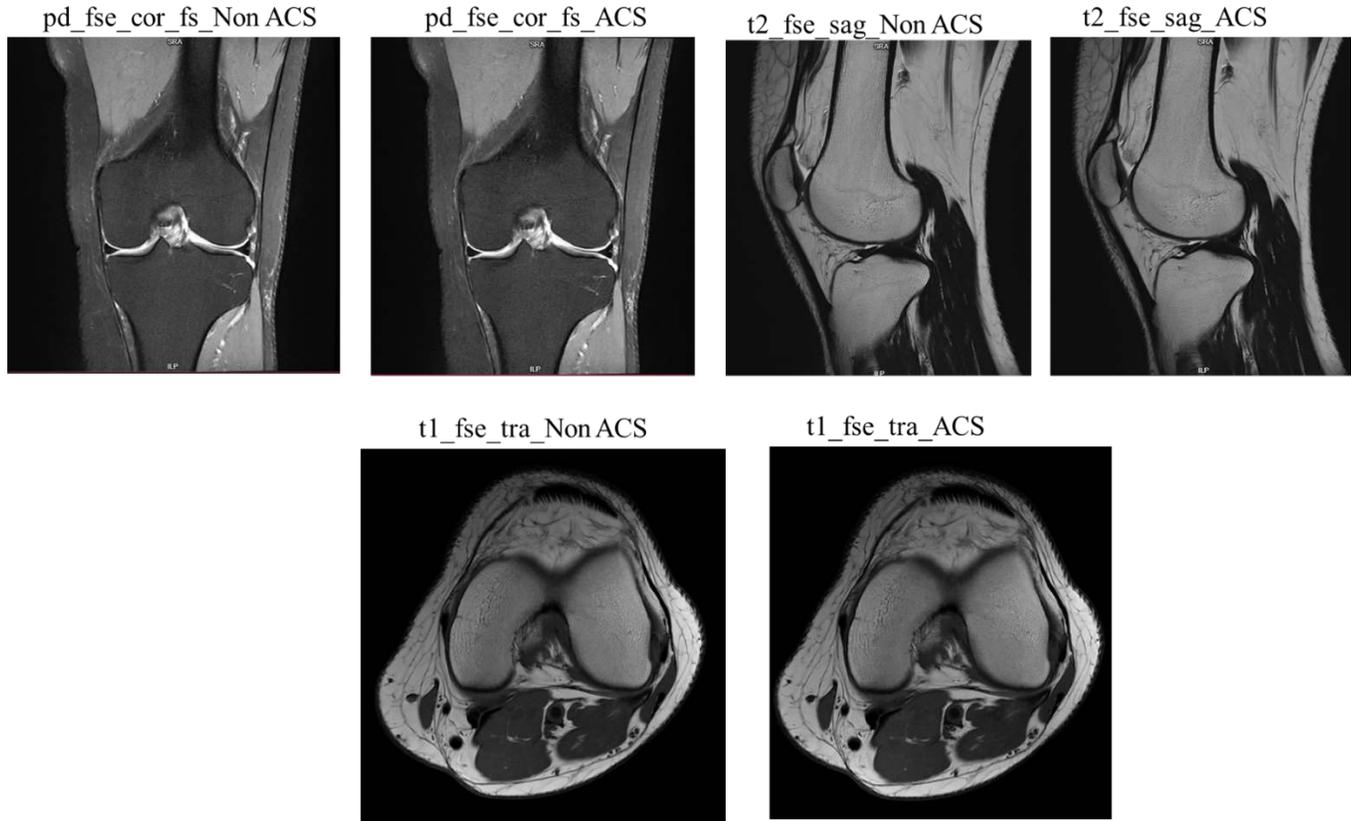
Knee MRI slices for all sequences of a representative subject.
